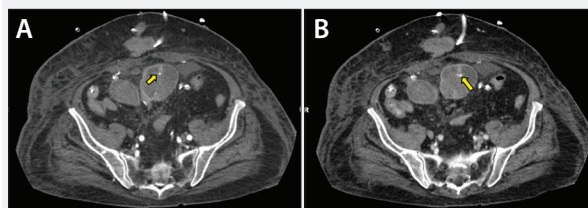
CTA showing a small focus of contrast extravasation within the lumen of a pelvic small bowel loop adjacent to the anastomotic staple line (arrows). This is seen as a tiny focus in the arterial phase (A) and appears slightly larger in the portal venous phase (B).
